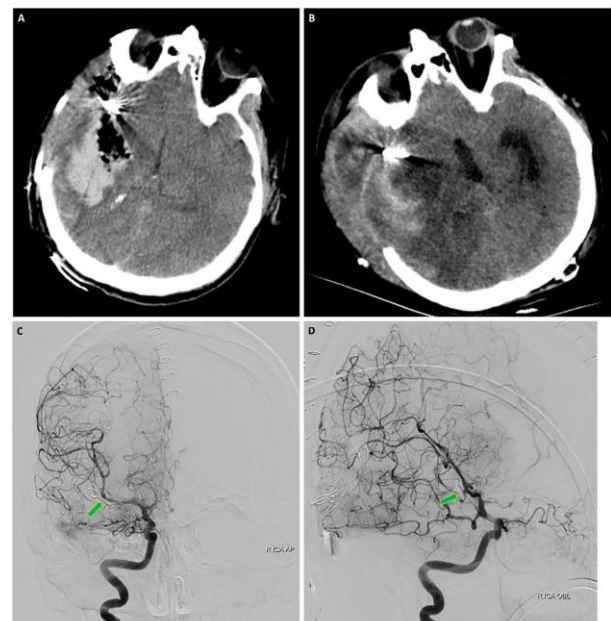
A-B. Cranial CT axial sections in the early and late postoperative periods; C-D. Postoperative DSA images showing severe vasospasm and right middle cerebral artery aneurysm clipped without remnant.
